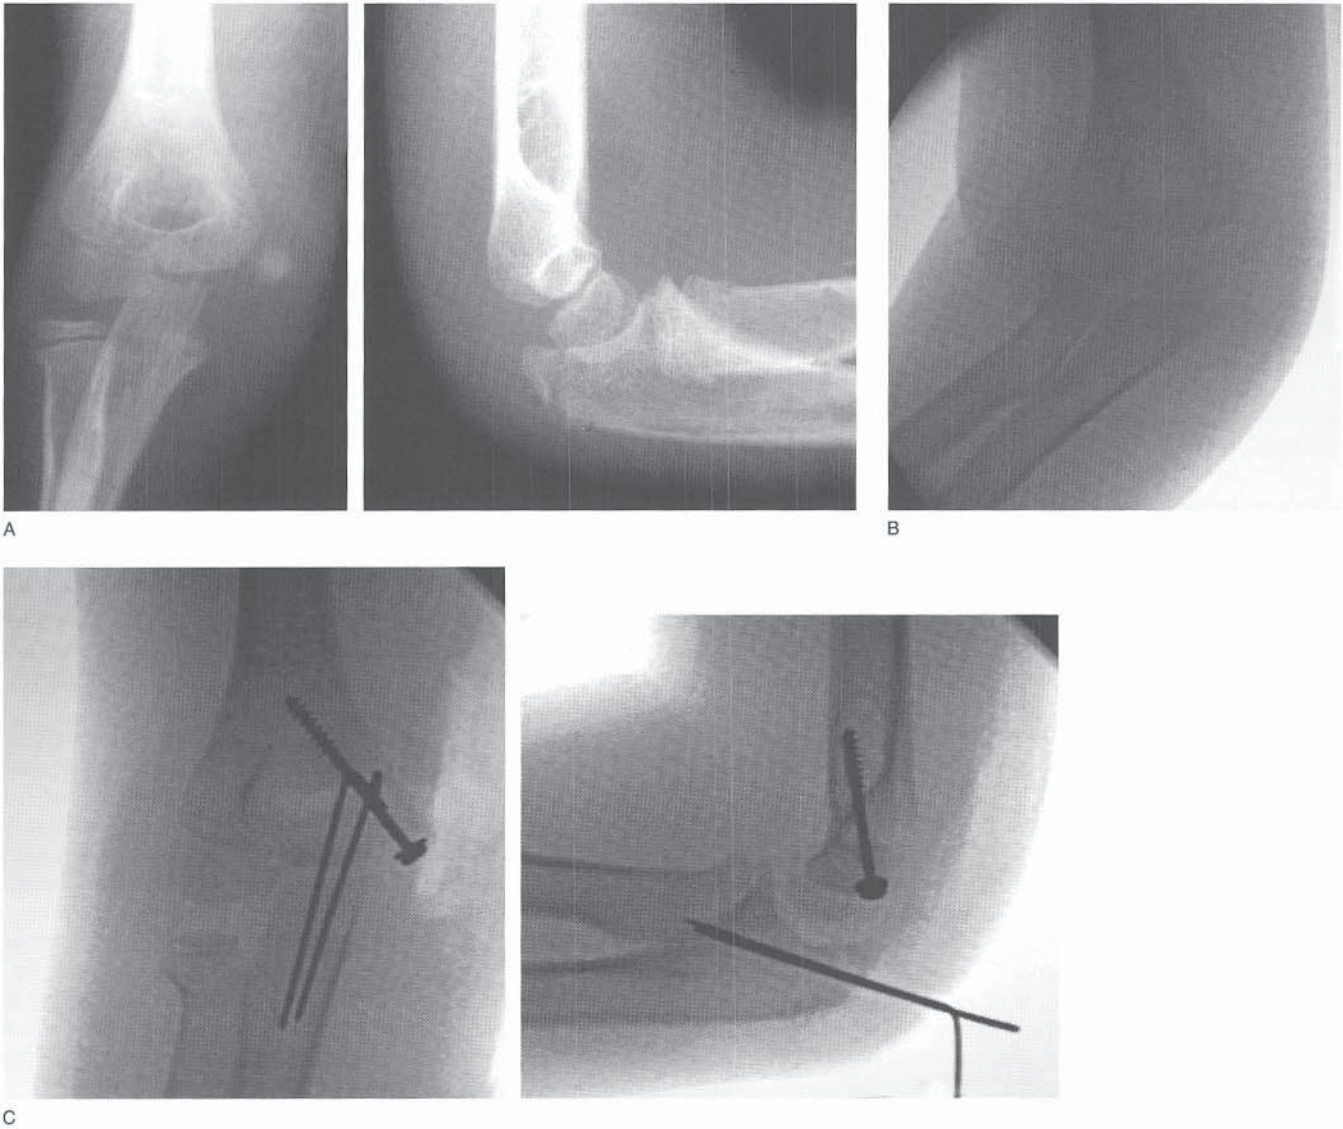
A, AP and lateral radiographs of an olecranon fracture with an associated medial epicondyle fracture, the result of a valgus hyperextension injury (which may have been an elbow dislocation) that spontaneously reduced. B, Intraoperative stress radiograph showing significant valgus instability. C, The patient was treated with open reduction and internal fixation of the medial epicondyle fragment. The alignment of the olecranon was inspected through the medial incision and the olecranon fracture was percutaneously pinned prior to fixation of the medial epicondyle.
